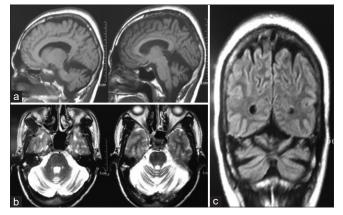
MRI images (a) T1 sagittal, (b) T2 axial and (c) FLAIR coronal of the patient showing moderate pan cerebellar atrophy
